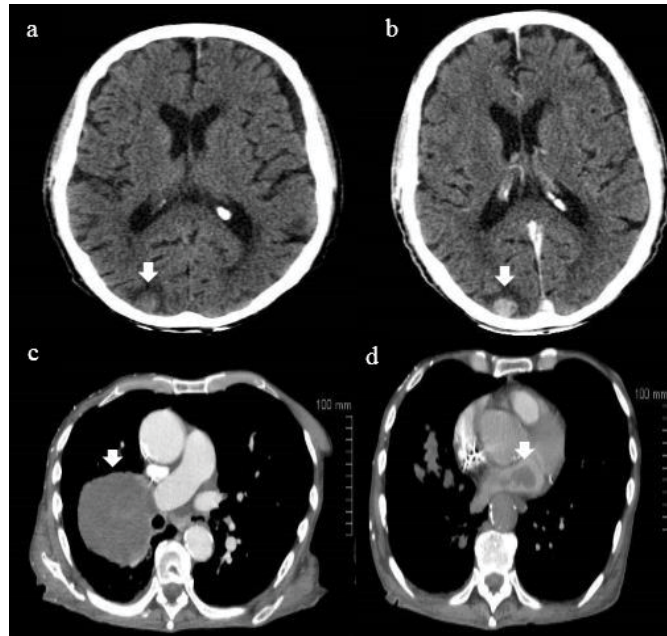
Brain computed tomography (CT)
